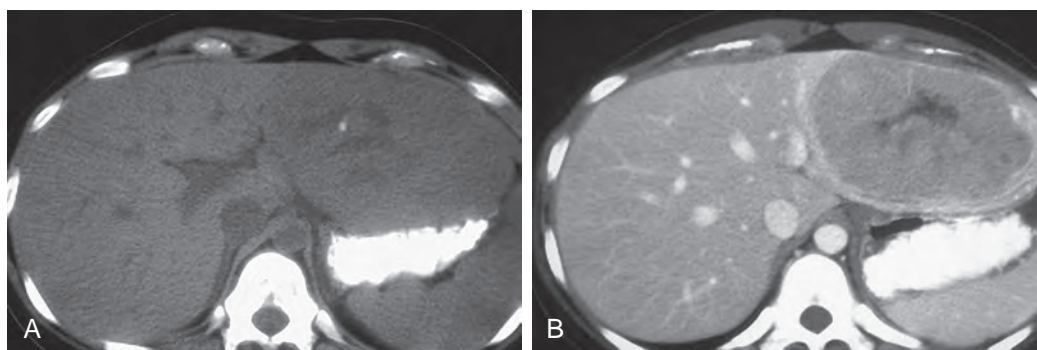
FLC: CT findings. A. This noncontrast scan shows calcification of the central scar. B. The central scar is better appreciated on this contrast-enhanced scan.
